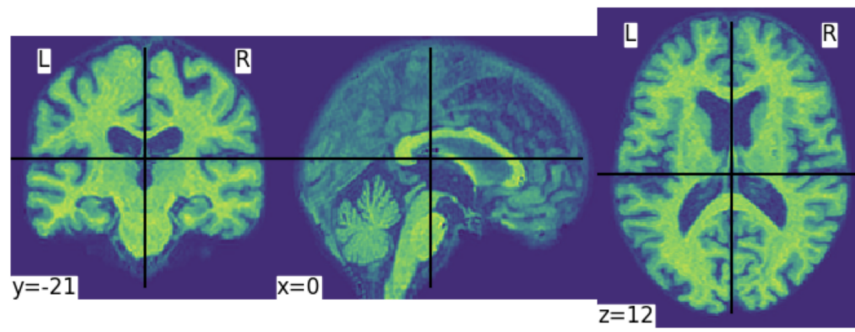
Preprocessed MRI image of CN subject
